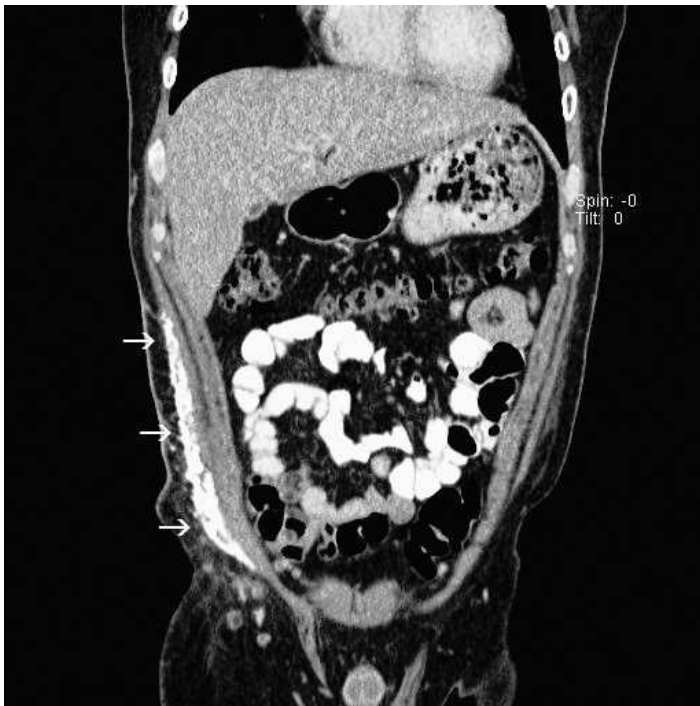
Coronal view of computed tomography showing extensive calcification of right flank.
